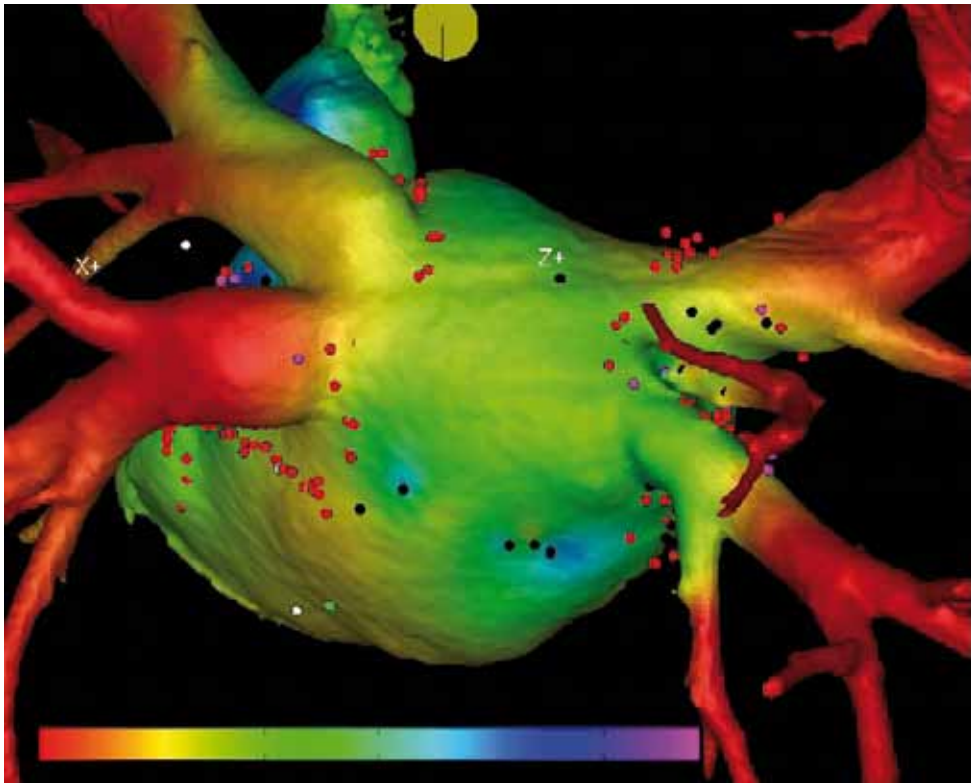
Example of integrated multimodal map obtained by registration and fusion of the CT left-atrium anatomic surface with an electro-anatomical voltage map.
